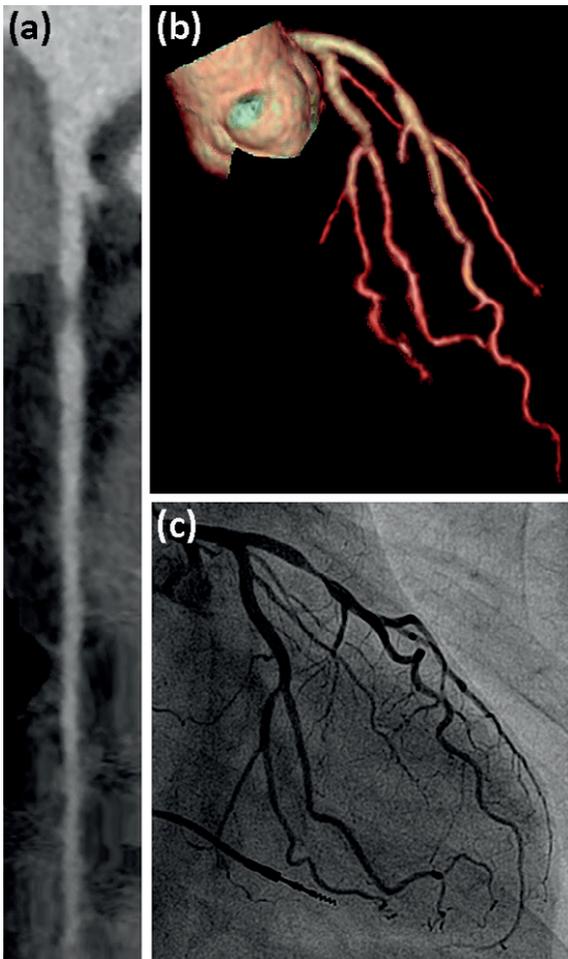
A 61-year-old female smoker (body mass index = 18.7 kg/m²) complained about recurrent atypical chest pain and was referred for exclusion of coronary artery disease. The patient was scanned at a heart rate of 62 beats/min and was exposed to 0.2 mSv of radiation dose and 25 mL of contrast agent volume. Coronary computed tomography angiography revealed a subtotal stenosis in the proximal LAD in the multiplanar reformations (a) and in three-dimensional volume-rendered image (b). The diagnosis was confirmed by invasive coronary angiography (c), and the patient was successfully
